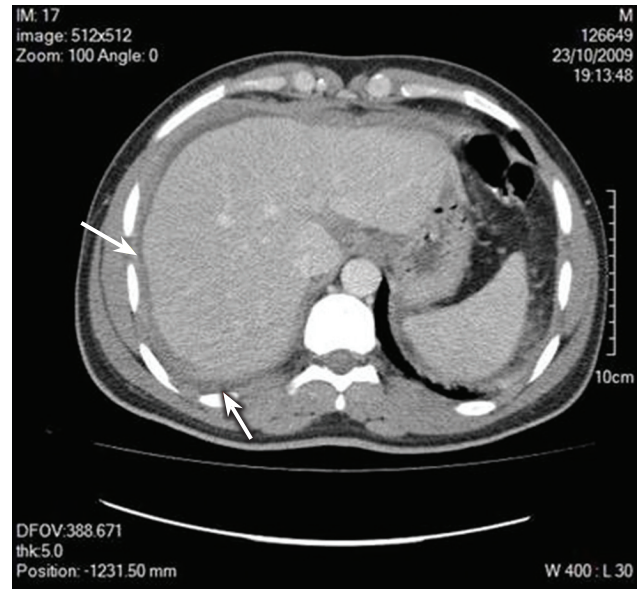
Contrast-enhanced abdominal CT showed scalloping of the liver contour (upper arrow), ascites and right-sided pleural effusion with accompanying atelectasia of the adjacent lung parenchyma (lower arrow).
